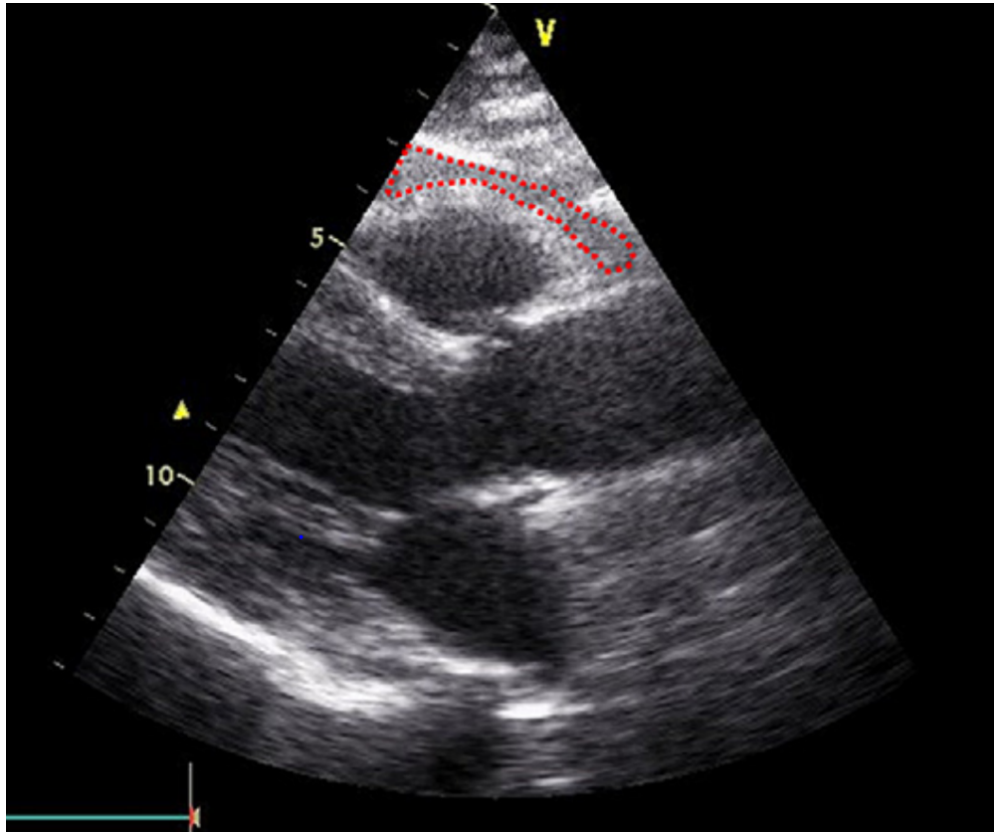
Epicardial fat thickness by 2D echocardiogram in modified parasternal view. (Dashed lines represent epicardial fat structure).
